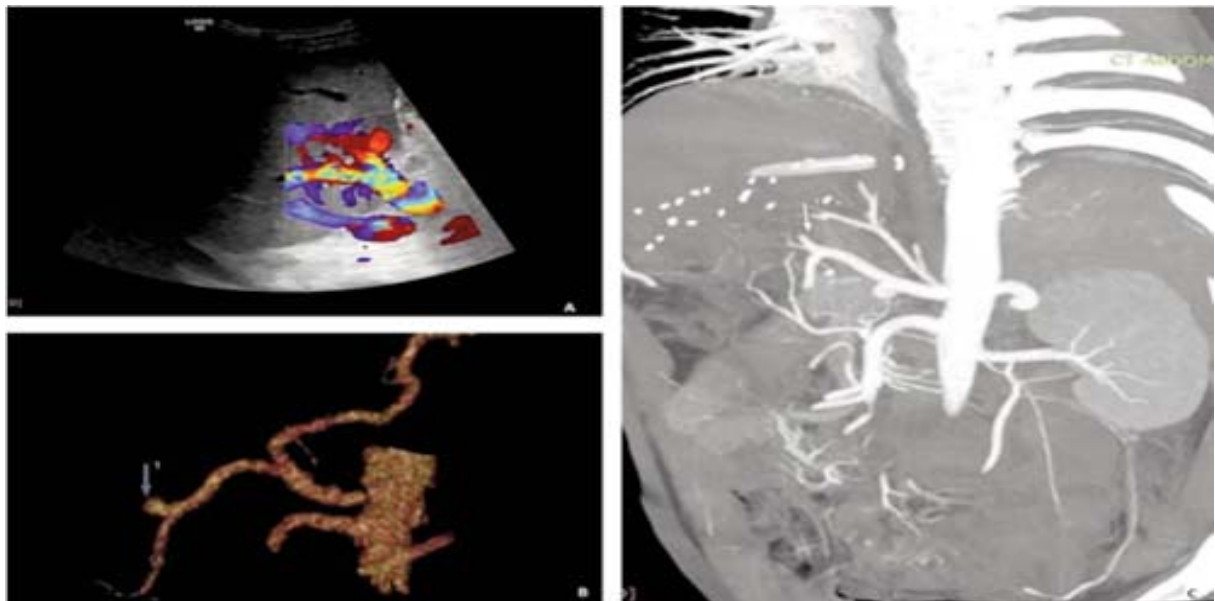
35-year-old male with hepatic artery thrombosis on 3rd post-operative day after living donor liver transplant (LDLT). A) Colour Doppler ultrasound (US) image of the transplanted liver at porta hepatis demonstrates blood flow in the portal vein, right hepatic veins (RHV) and inferior vena cava (IVC), but no Doppler-detectable blood flow is noted in the hepatic artery, indicative of hepatic artery occlusion. B) Three-dimensional (3D) virtual reality (VR). C) Coronal Multiplanar reconstruction (MPR) images showing abrupt cut-off of the hepatic artery (arrows) at the porta hepatis without any extension into the liver, hence confirming hepatic artery thrombosis (HAT).
